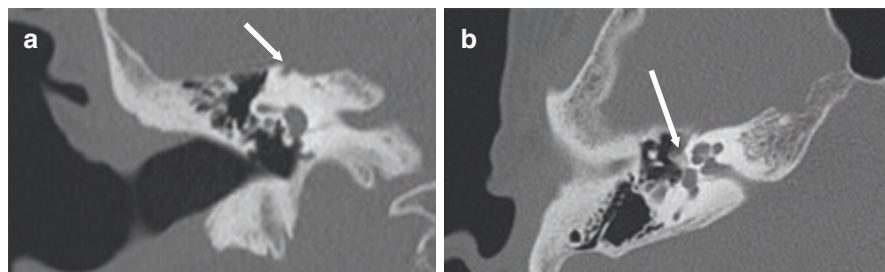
Coronal CT demonstrating SCD (a). Axial CT displaying hypodensity of fissula ante fenestram (b). CT indicates computed tomography. (Image courtesy of Eric Sargent, MD, FACS)
